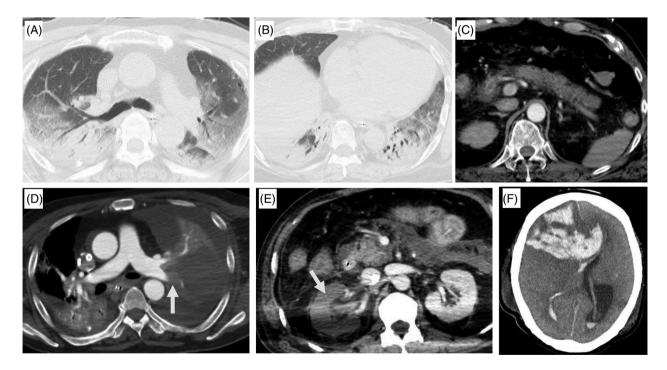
Serial computed tomography (CT) scans of the patient. Chest CT performed immediately after the transfer of the patient to our hospital showing bilateral consolidations, ground-glass opacities and atelectasis in lungs (A, B). Abdominal CT showing pancreatic enlargement (C). Severe pneumonia due to coronavirus disease 2019 (COVID-19) and secondary pancreatitis were identified. CT scan of the thorax and abdomen on day 29 showing complete atelectasis of the left lung and left pulmonary thromboembolism (arrow) (D), and right renal infarction (arrow) (E). CT scan of the head on day 34 showing subcortical haemorrhage in the right frontal lobe (F)
